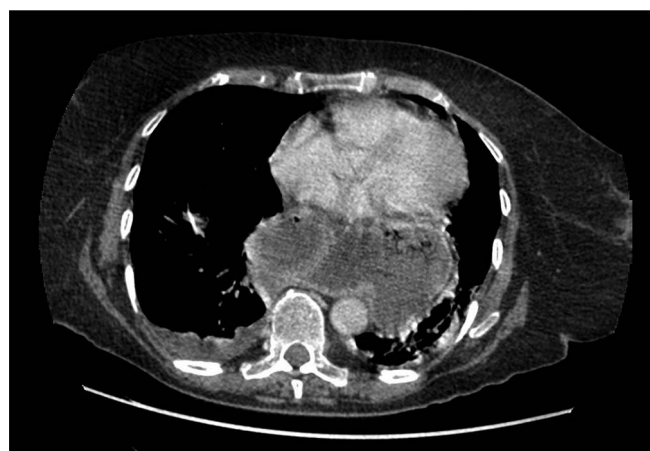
Sagittal CT view of a large para-esophageal hernia with most of the stomach in the Mediastinum.
